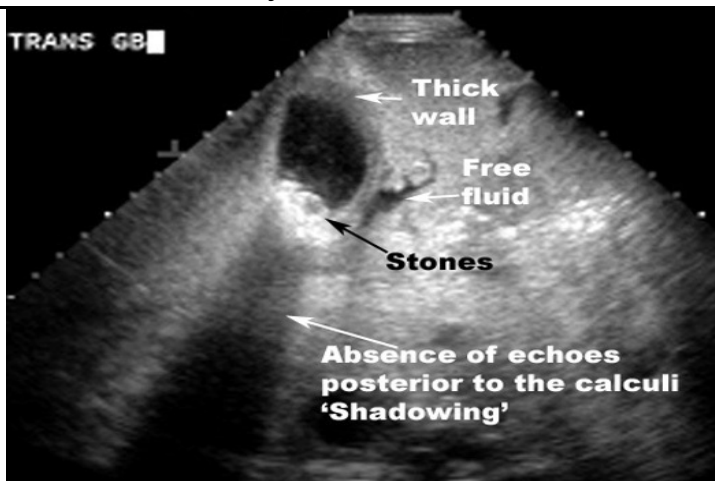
Ultrasound findings: thick gallbladder wall, stones in gallbladder, absence of echoes posterior to the calculi -“Shadowing”
